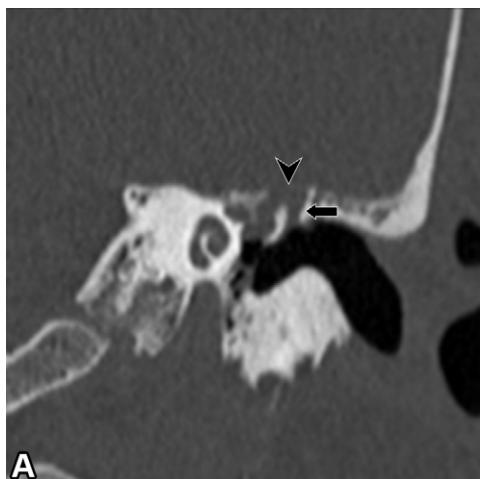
Cholesteatoma in a 43-year-old patient with left-sided hearing loss. (A) Coronal CT image of the temporal bone shows opacification of the epitympanum including the Prussak space (arrow) and dehiscence of the tegmen tympani (arrowhead). (B, C) Axial diffusion-weighted (B) and apparent diffusion coefficient (C) images from subsequent MRI show restricted diffusion in the middle ear (arrow). The patient underwent mastoidectomy, resection, and skull base resurfacing. Pathologic analysis demonstrated a cholesteatoma.
